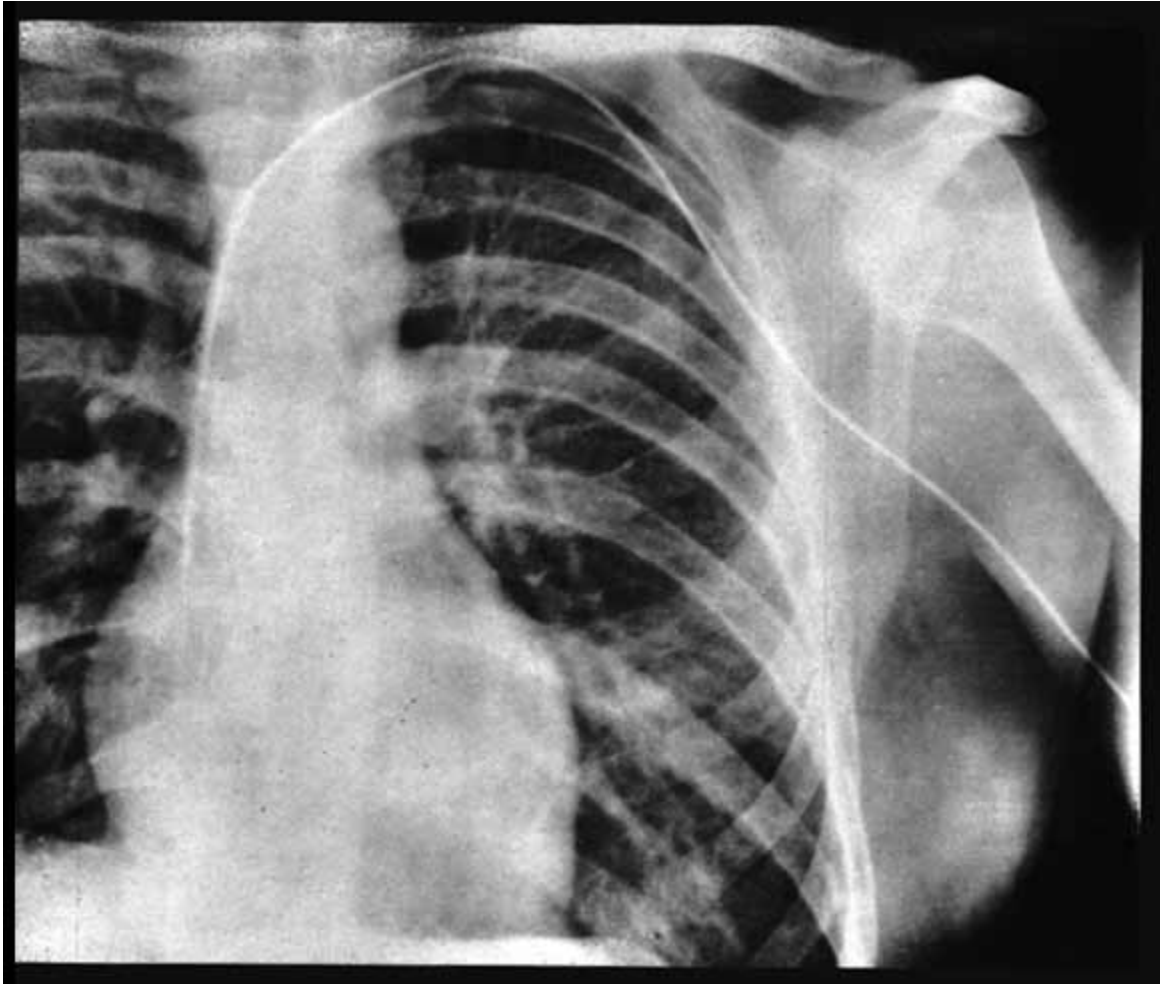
Original X-ray of a urinary catheter in Werner Forssman's right atrium (Meyer, 1990)
